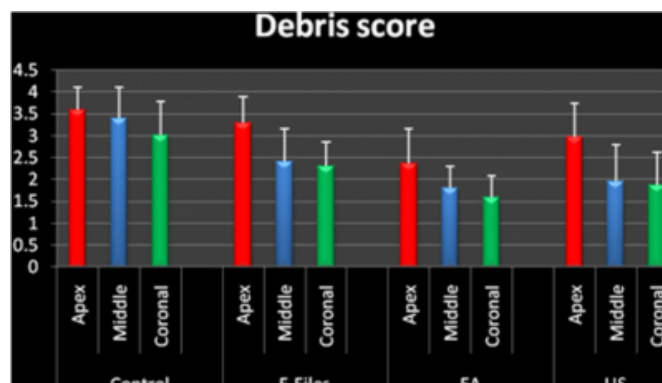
Dentin debris score (0-4) after activation of irrigation solutions (6.15% NaOCl and EDTA) with F-Files, EndoActivator (EA), Ultrasonic (US) and Control group (no activation).
